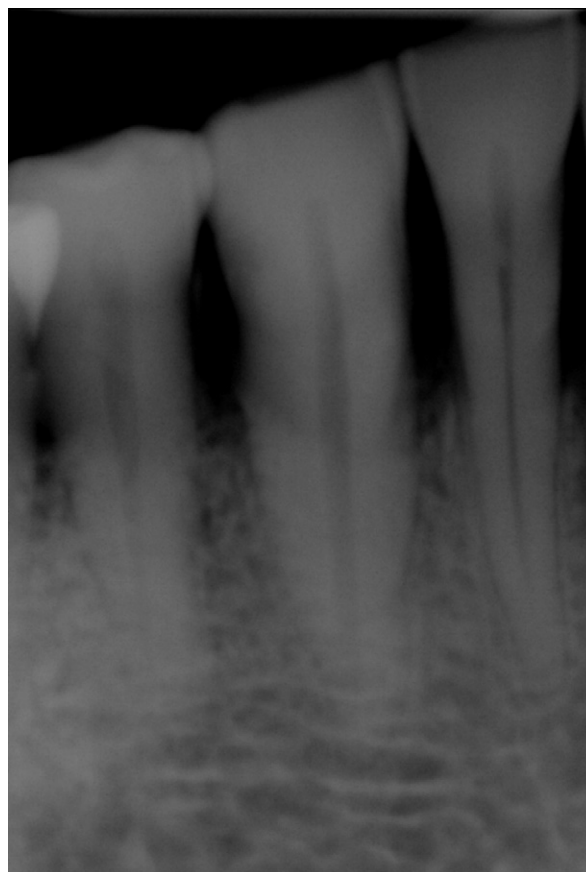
Intraoral periapical radiography obtained by Progeny CCD sensor.
